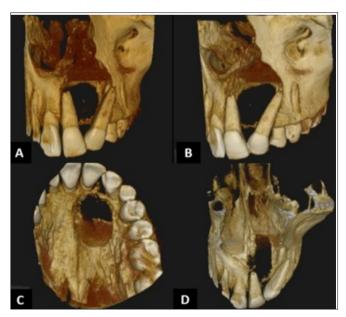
3D reconstruction of cone beam tomography showing the limits of the lesion and its relationship with noble structures.
